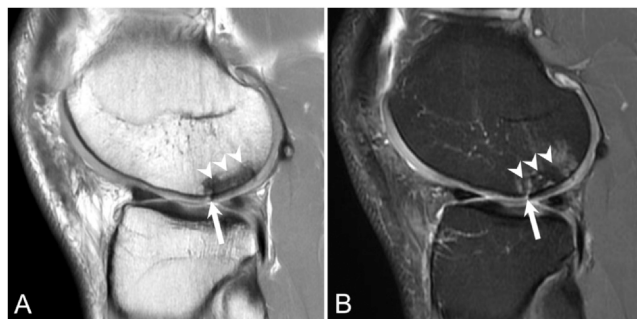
Professional football linebacker presents for pre-employment physical. Sagittal PD (A) and sagittal T2 FS (B) MR images demonstrate evidence for cartilage repair at the posterior weightbearing aspect of the lateral femoral condyle (arrowheads in A and B). The graft is appropriately positioned, and the overlying graft cartilage is intact and congruent with the adjacent native hyaline cartilage. There is minimal chondral fissuring at the anterior graft-cartilage interface (arrow in A and B). FS, fat saturation; MR, magnetic resonance; PD, proton density.
